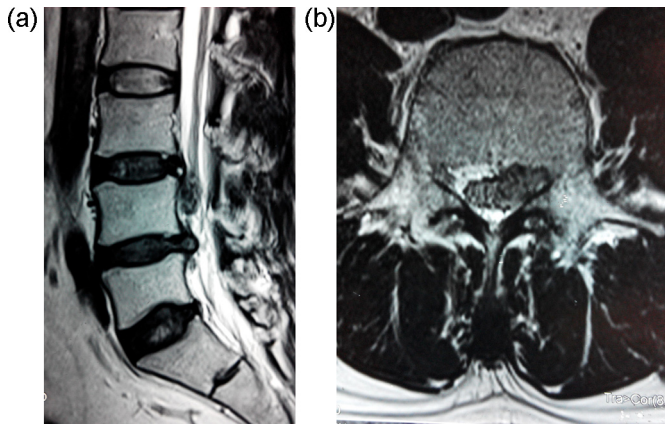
Sagittal (A) and Axial (B) T2-weighted MRI of the lumbar spine images show a large extruded disc fragment on the left side at the L3–L4 level.
